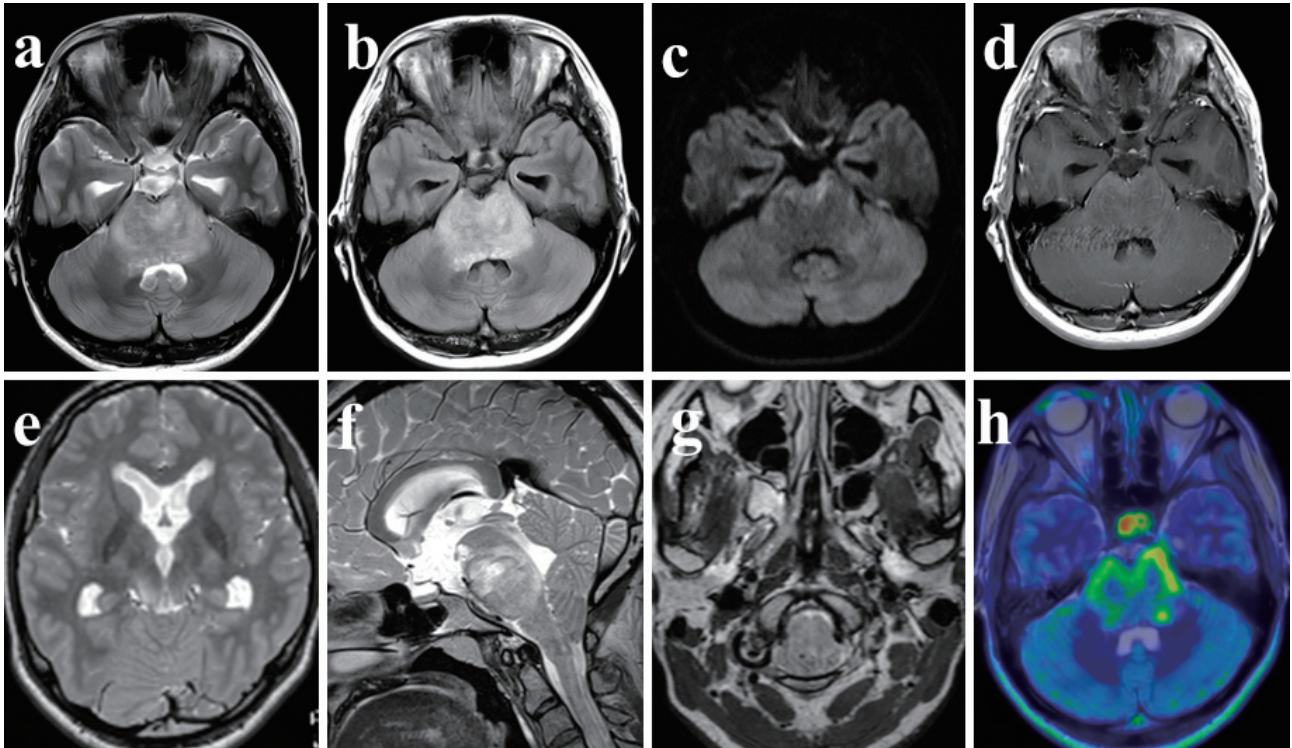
Preoperative magnetic resonance imaging (MRI). a, b: Axial images of the T2-weighted and T2-FLAIR (fluid-attenuated inversion recovery) showing diffuse hyperintense swelling of the brainstem c: Diffusion-weighted image showing spotty high intensity in the ventral pons. d: T1-weighted gadolinium (Gd)-enhanced MRI showing no apparent contrast enhancement in the tumor. e-g: T2-weighted MRI showing enlarged lateral ventricles due to CSF obstruction with tonsillar herniation in the posterior fossa. h: ^{11}C -methionine was partially concentrated in the sites of the pons on position emission tomography (PET) scan.
